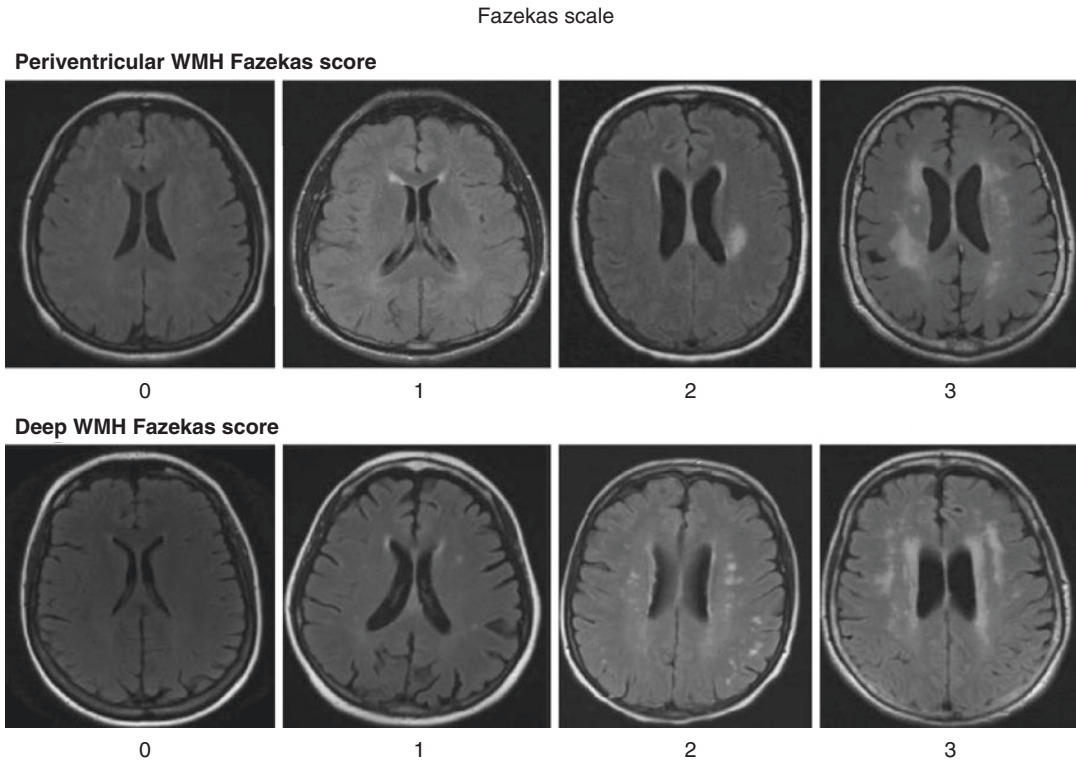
Fazekas scale in brain MRI. Adapted with permission from Radiation Oncology, Copyright Springer Nature [27]
